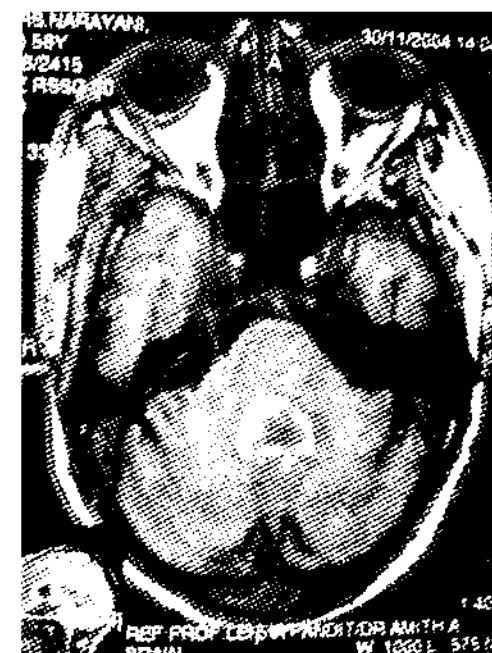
CT scan images of cerebral haemorrhage
